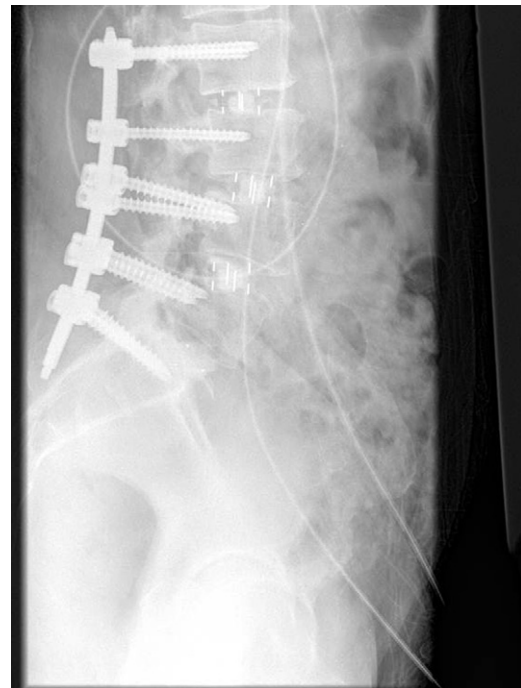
Lateral postoperative radiograph.
